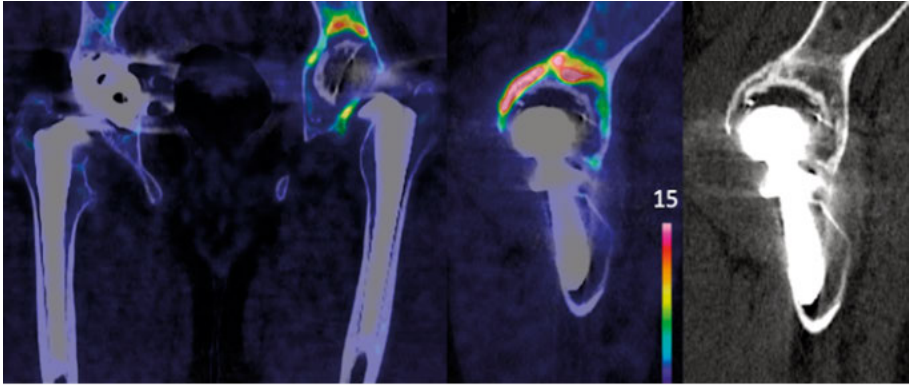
Representative ^{18}F -fluoride PET/CT imaging in total hip arthroplasty. The fused PET/CT image demonstrates focally increased periprosthetic tracer uptake around the acetabular component in a 42-year-old male patient with suspected cup loosening. Quantitative analysis showed higher metabolic activity in the acetabular component (SUVmax 26) compared with the femoral stem (SUVmax 6). The findings are consistent with increased bone turnover associated with acetabular loosening, while femoral stem loosening was reported and later confirmed as well fixed.
